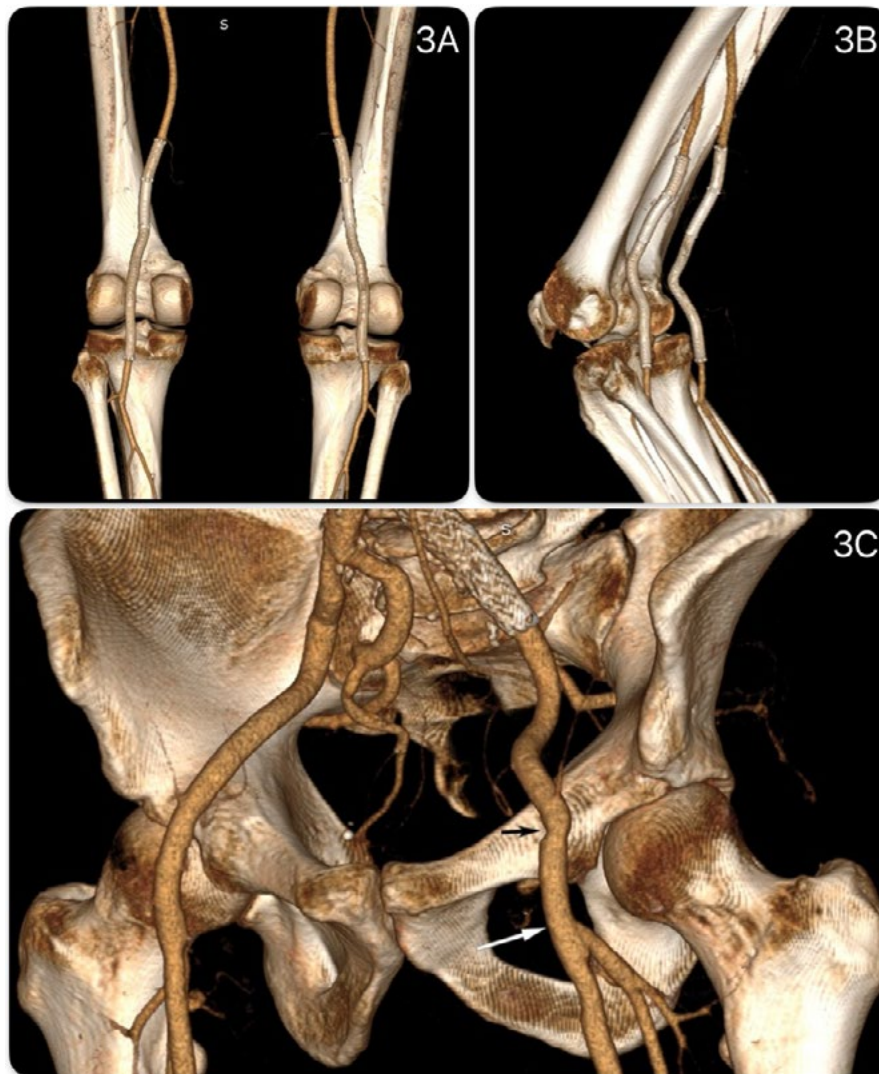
A. 3-dimensional reconstruction of postoperative CT angiography with limbs in extension B. Same with limbs in flexion. C. The surgical graft is shown with the black arrow indicating the level of the proximal and the white arrow the level of the distal anastomosis.
